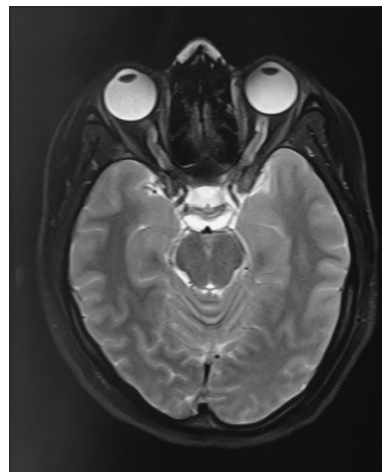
MRI brain (plain) axial images showing tortuous optic nerves with prominent peri optic CSF space
